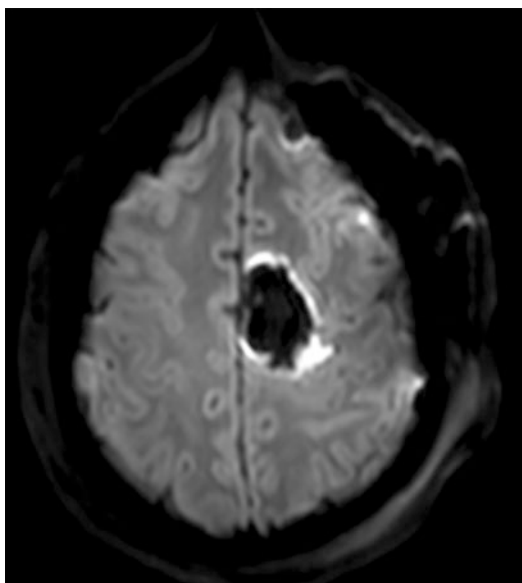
Candidate for postoperative nrTMS treatment. This axial DWI slide shows a patient after resection of an anaplastic astrocytoma WHO III in the SFG suffering from a severe surgery-related paresis of the right hand due to ischemia in the precentral gyrus. These patients are highly comparable to stroke patients who repeatedly showed to benefit from nrTMS treatment
